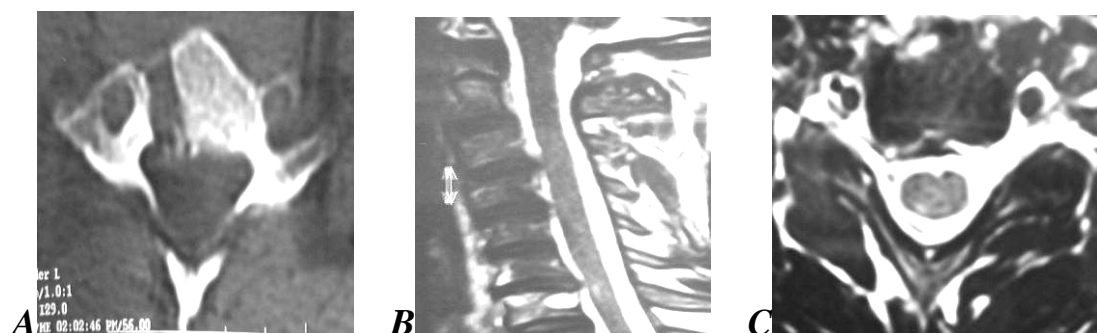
CT axial cut (A) and MRI sagittal (B) and axial (C) cuts at C6-7 level, showing complete removal of the disc osteophyte complex via lower vertebral transcorporeal approach.
